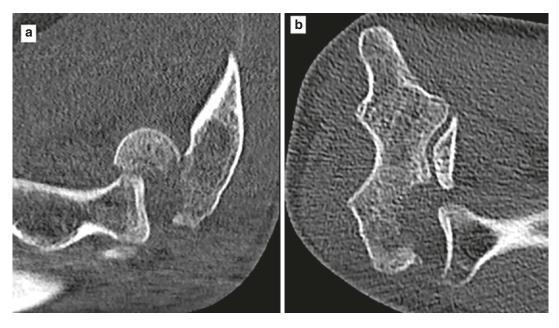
(a) Sagittal and (b) coronal CT reformatted images demonstrating a minimally comminuted capitellum fracture that was rotated through 90° to sit anterior to the radial head
